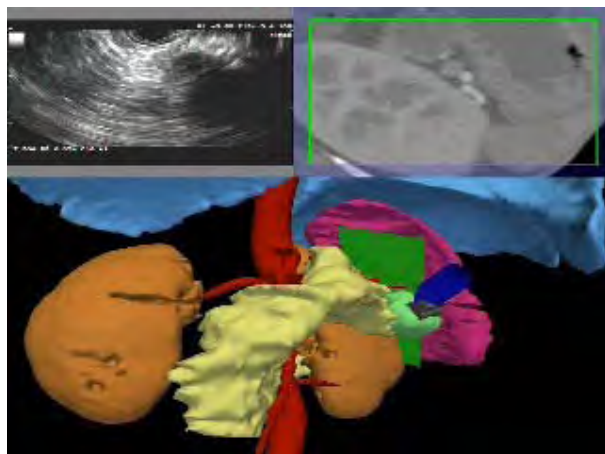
IRGUS display for a human patient: top left: b-scan ultrasound image. Right: reformatted CT data in US-defined plane. Bottom: 3D CT-based model of patient for navigation and biopsy probe positioning. The pancreas is yellow, the ultrasound image plane is green, and the kidneys are orange. The tip of the endoscope (blue) is tracked by an ATC MedSafe tracker.
